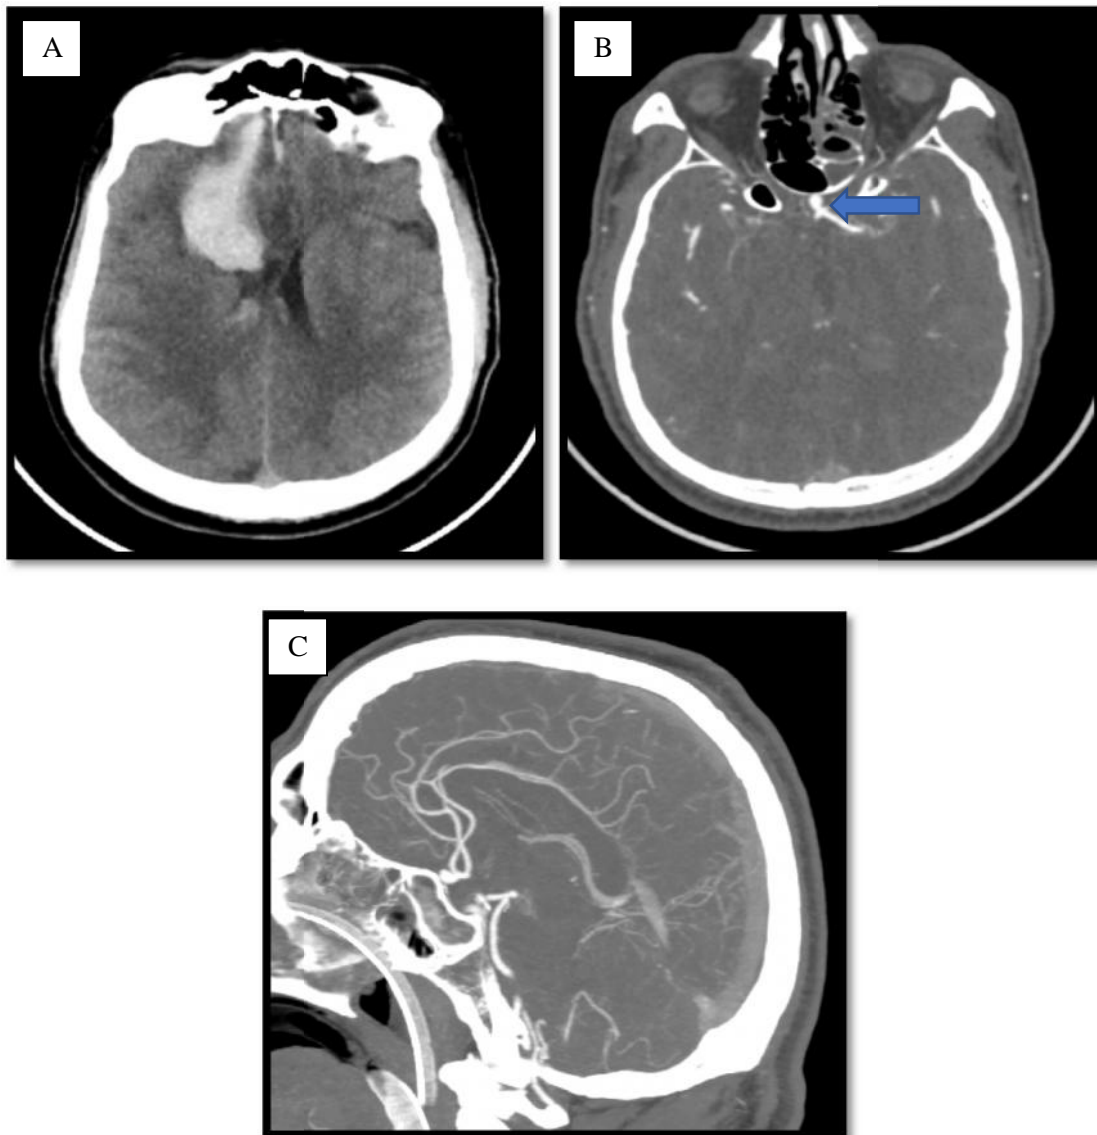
56 year old male patient with a ruptured ACOM aneurysm. A. Plain CT brain showing SAH and intraparenchymal hematoma in the right frontal region, B. Arterial phase C. Sagittal MIP of CTA showing ruptured ACOM aneurysm
